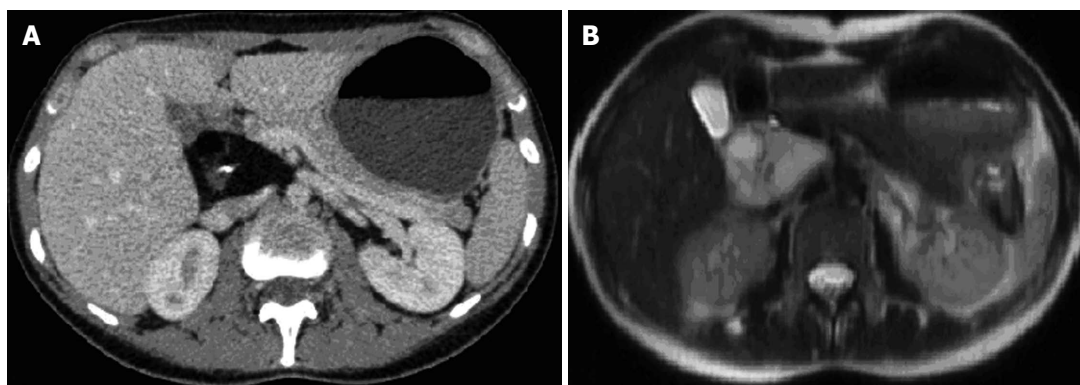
Cross-sectional imaging. A hepatoduodenal heterogeneous mass was revealed by A: Computed tomography; B: Magnetic resonance imaging.
